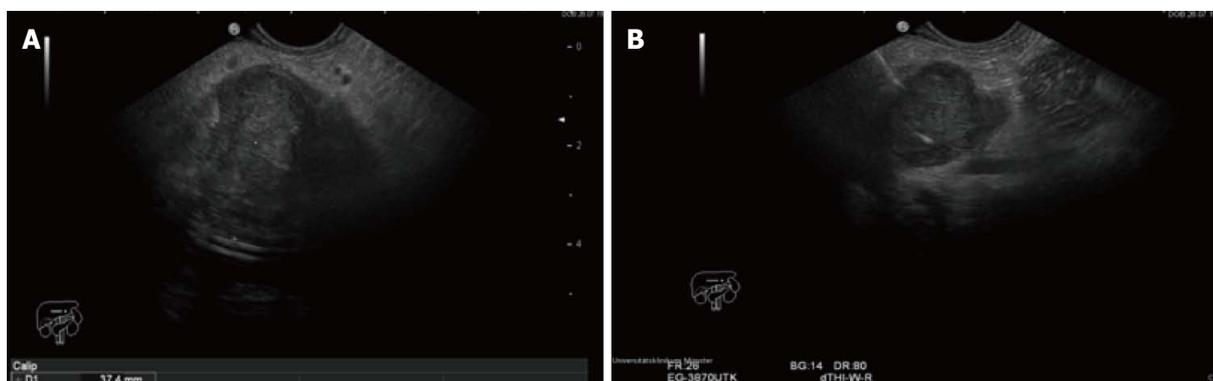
Endoscopic ultrasound radiofrequency ablation of pancreatic neuroendocrine tumors. A and B: Endoscopic ultrasound pictures of the pancreatic neuroendocrine tumors pre and during ablation.
